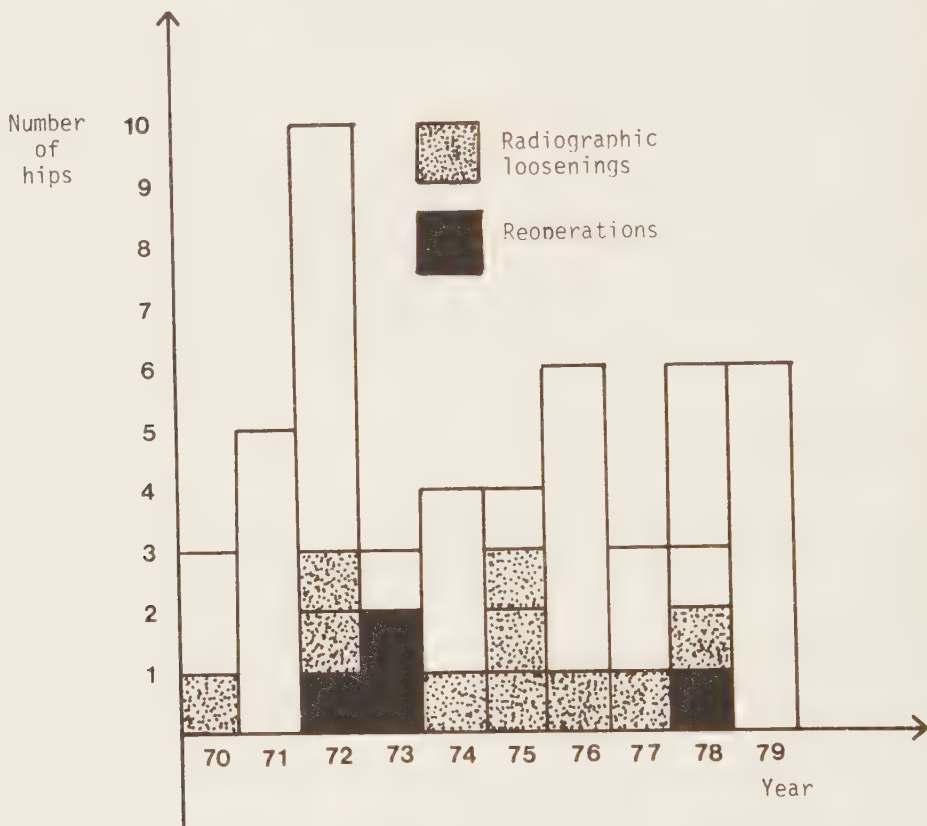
Fifty THR in JCA. The annual number of operations, radiographic loosening and non-infected reoperations during a ten-year period.
